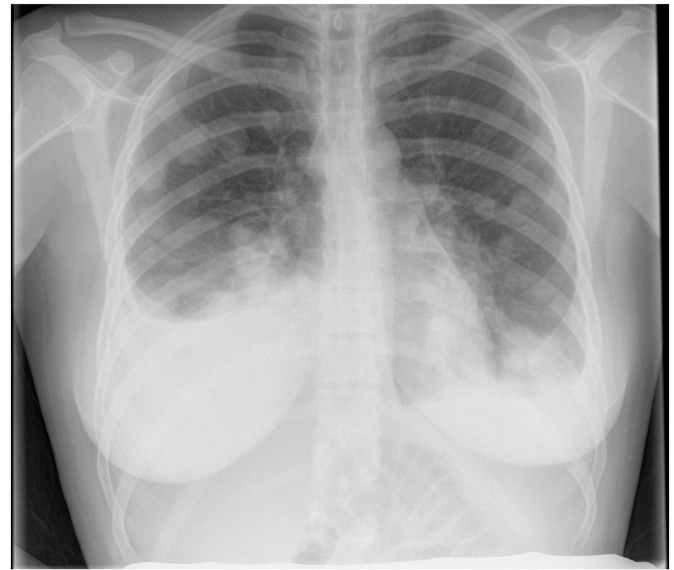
Chest radiograph: bilateral pulmonary nodes of up to 20 mm suggestive of metastases and bilateral pleural effusion.
